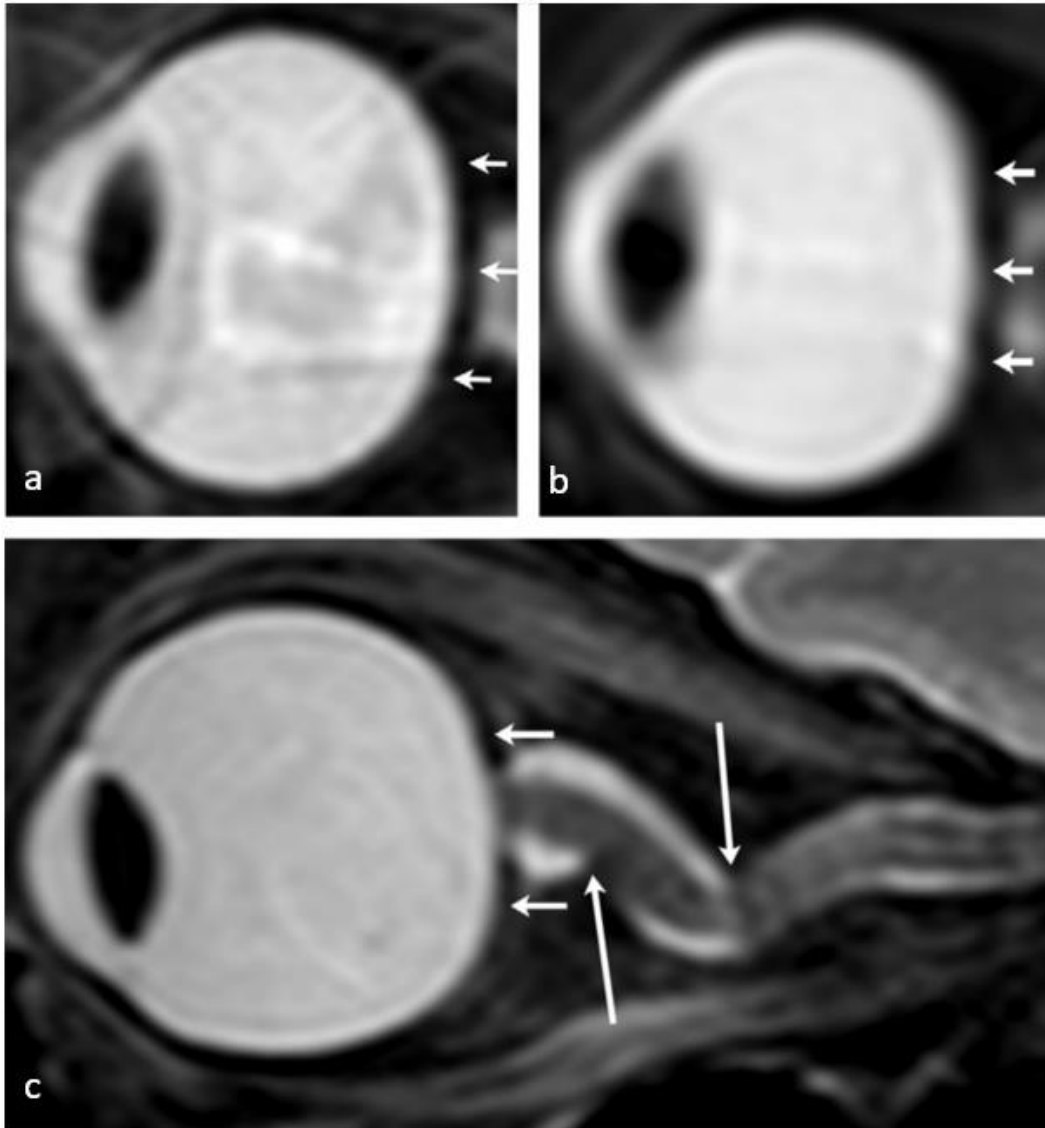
MR images highlighting globe flattening (short arrows) and nerve kinks (long arrows). An example pre-flight image (a) showing normal posterior globe surface and the associated post-flight image (b) for one astronaut. c) highlights a severe case of ON kinking in an astronaut after spaceflight (figure from 15).
